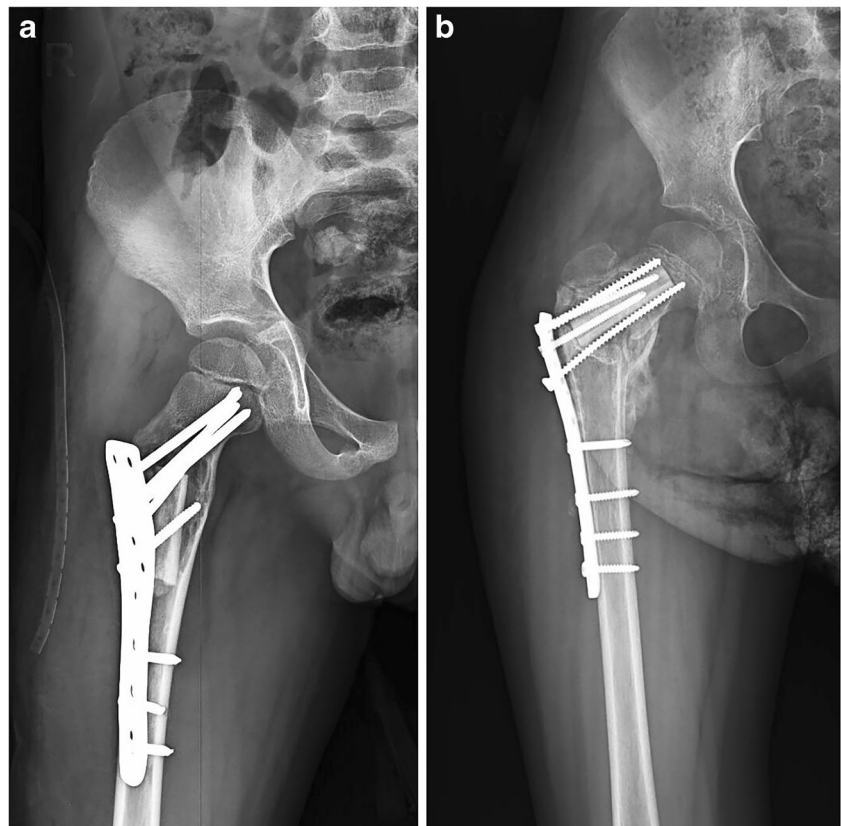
a Anteroposterior radiograph of a Dormans type IB unicameral bone cyst (UBC) showing placement of fibular strut graft in the femoral shaft. b Lateral radiograph of a type IIB UBC showing placement of fibular strut graft in the femoral neck
